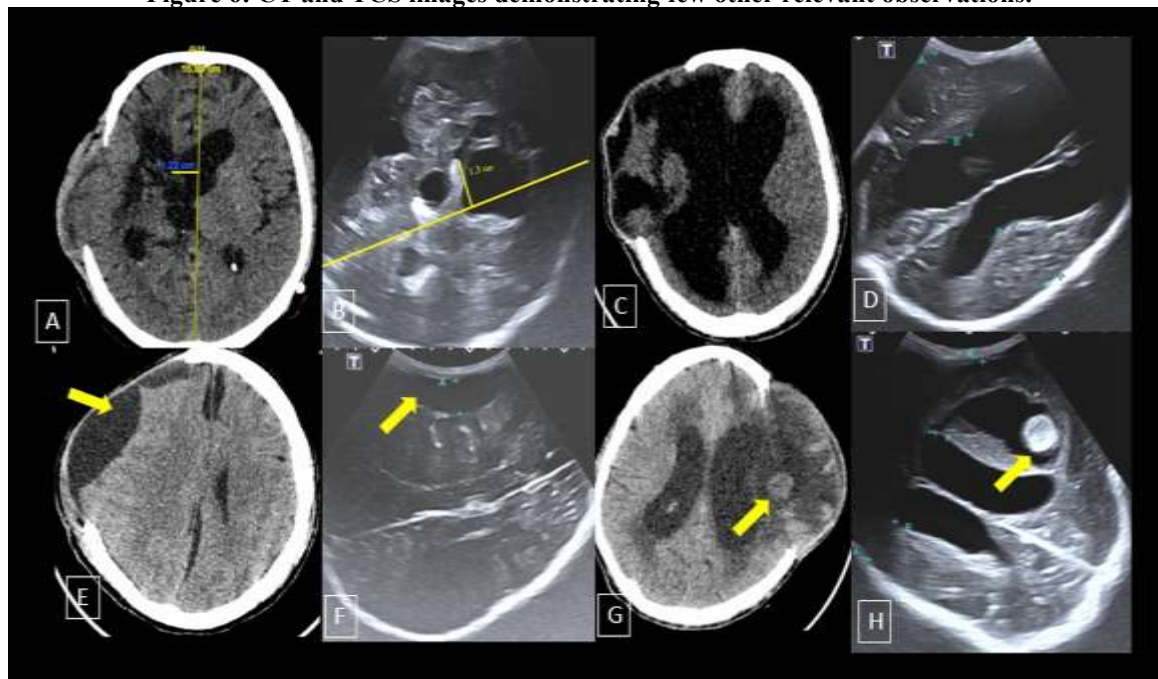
Images A & B demonstrate MLS. Anatomical midline is first drawn (long yellow line on CT and TCS). The distance of the displaced septum pellucidum from the midline is drawn (small yellow line on both). There is a MLS midline shift of 1.3 cm to the right.
